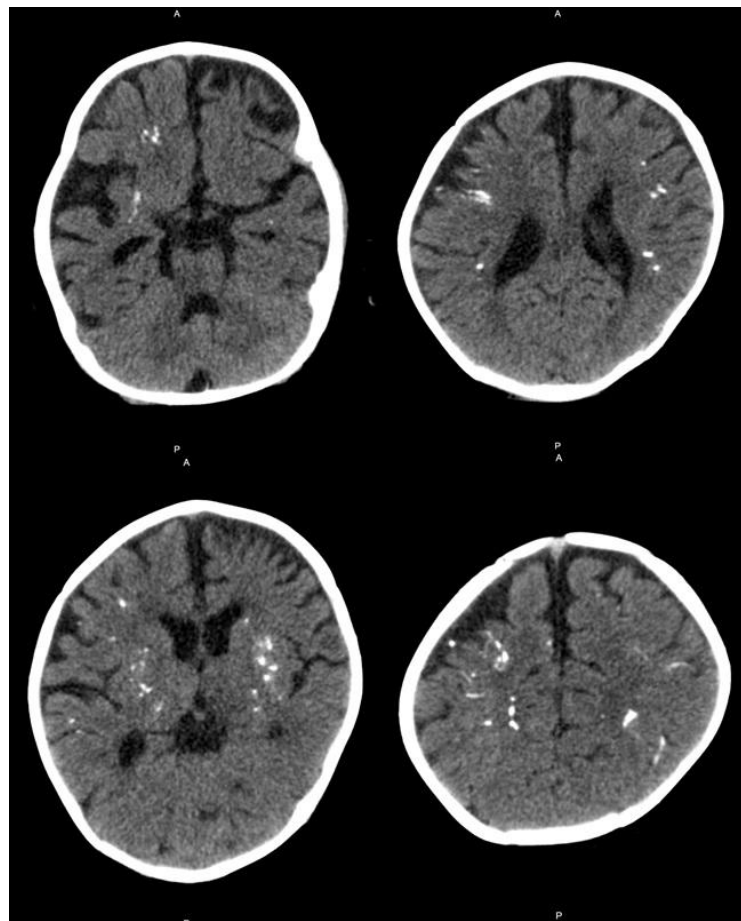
CT scan depicting multifocal intracranial calcifications -TORCH infection
